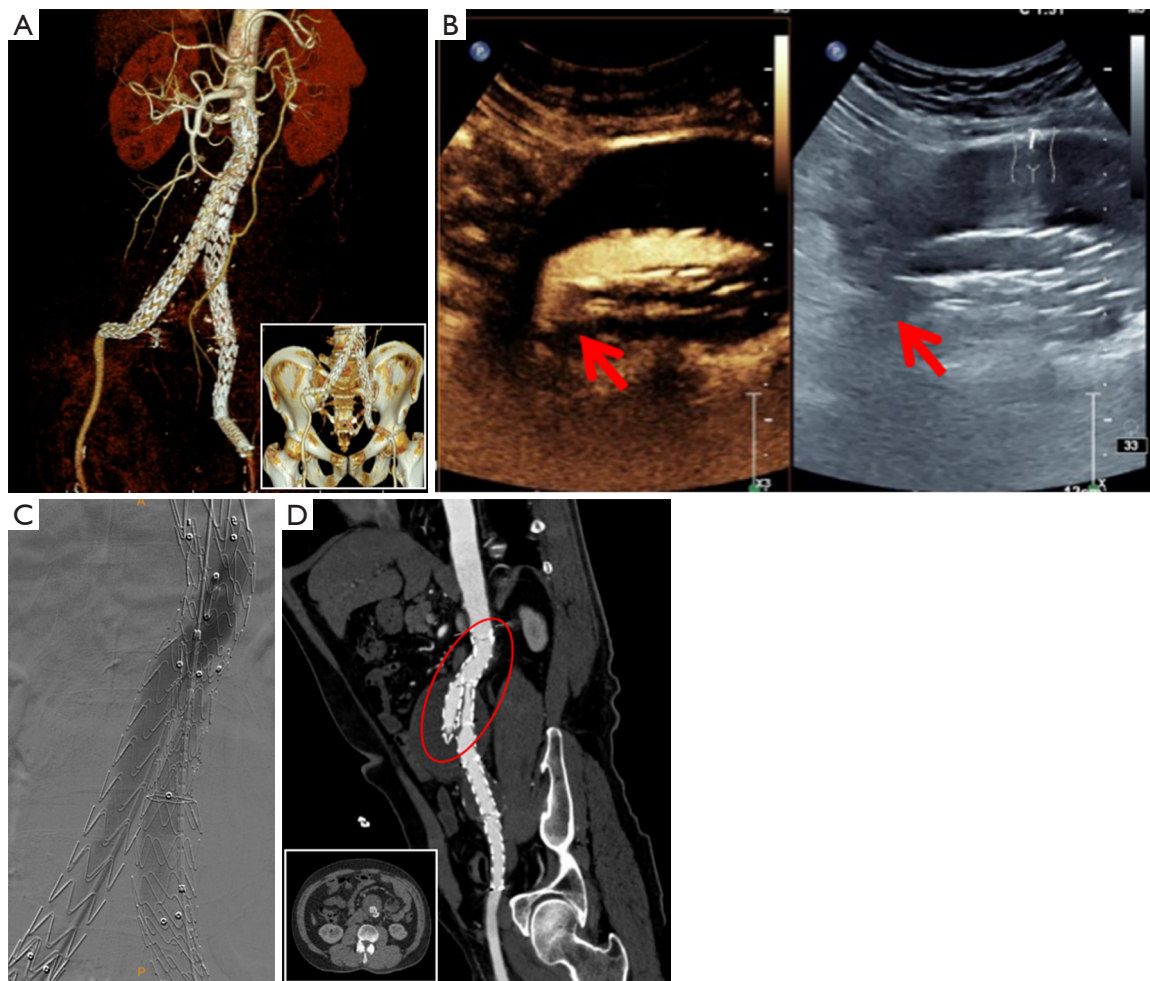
CTA and CEUS images before the second IBO operation and DSA images during the operation. In March 2021, CTA after symptom recurrence indicated that the left iliac branch was occluded again (A). Preoperative CEUS showed that there was no obvious stenosis in the proximal end of the left iliac branch as shown by the arrow (B). DSA showed that there was obvious marginal laminar flow in the left iliac branch and the blood flow velocity decreased (C). This phenomenon could also be observed indirectly through the reconstructed images of CTA (D). Mural thrombus can be seen in the stent of the proximal iliac branch as shown in the circle. CTA, computed tomography angiography; CEUS, contrast-enhanced ultrasound; IBO, iliac branch occlusion; DSA, digital subtraction angiography.
